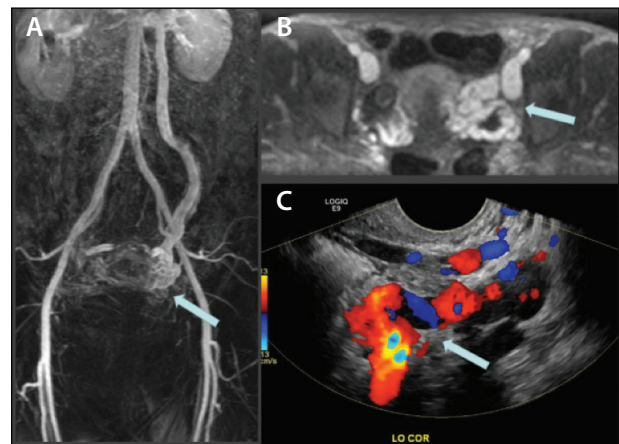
MRA (A, B) demonstrates dilated left OV and enlarged tortuous venous varicosities around the adnexa and in the pelvic floor (arrows). A transvaginal Doppler ultrasound (C) shows multiple dilated veins (“venous lakes”) around the ovaries and uterus (arrow).
